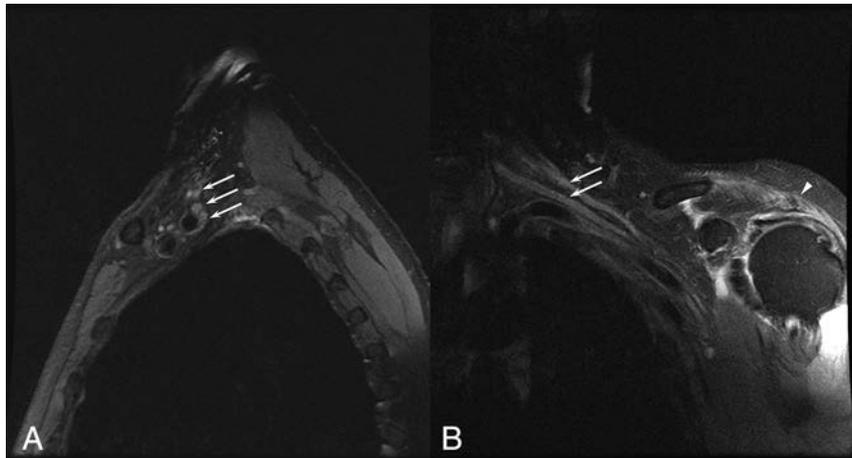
A 75-year-old man with a left brachial zoster-associated plexopathy. *A*, Sagittal T2-weighted image with fat saturation demonstrates diffusely increased T2 in the upper, middle, and lower trunks of the brachial plexus (arrows). *B*, Coronal T2-weighted image with fat saturation demonstrates increased T2 in the upper and middle trunks of the brachial plexus (arrows). Prolonged T2 associated with denervation is noted in the deltoid (arrowhead).
